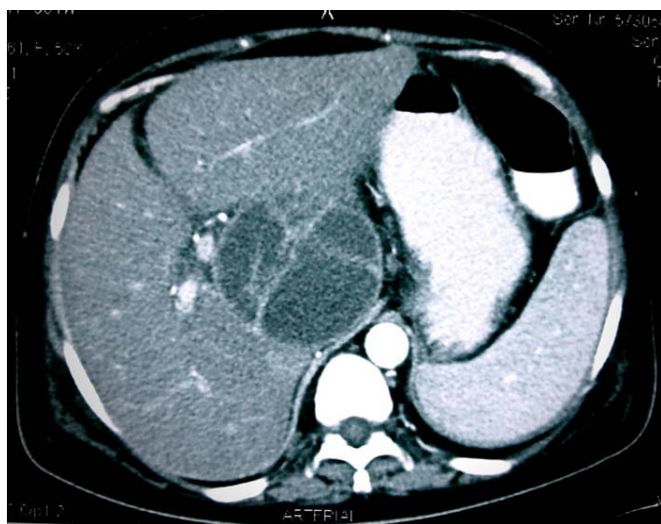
CT scan showing a cystic mass at the porta hepatis giving appearance of a cystic neoplasm.
